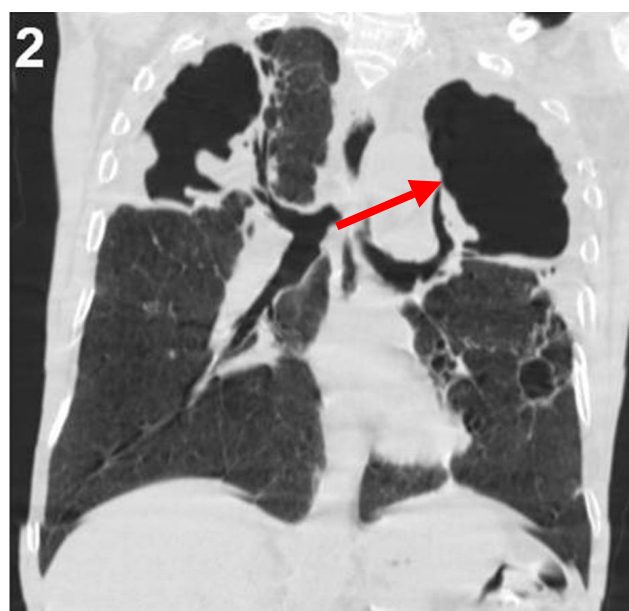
Upper-lobe predominance of irregular thick-walled cavities and their bronchial communication had been underlined by Computed tomography (coronal Minimum-Intensity-Projection reformat)
